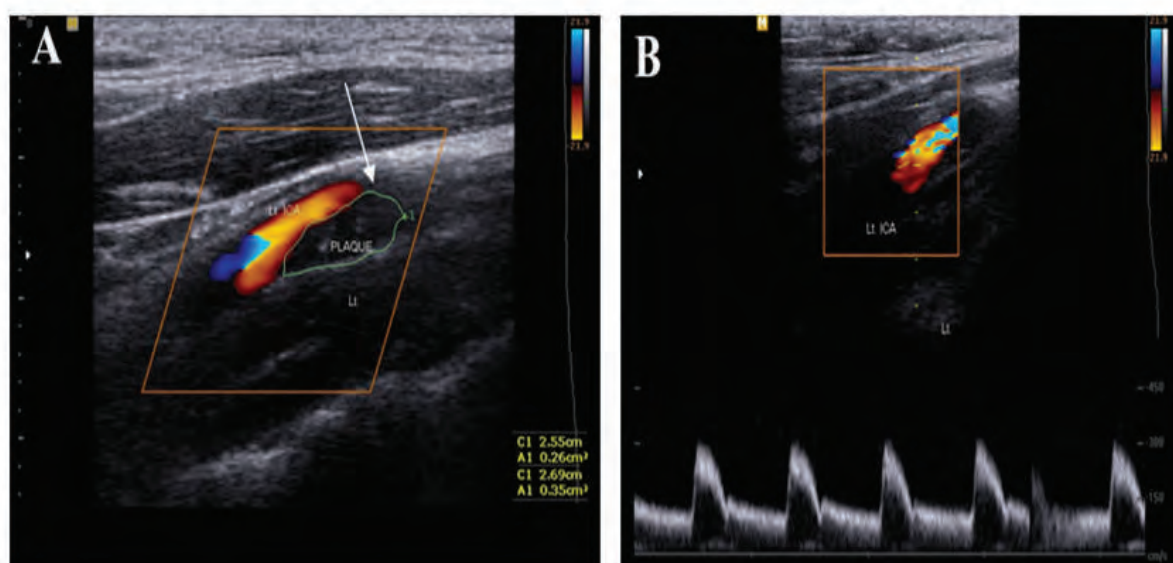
Colour duplex ultrasound of left carotid arteries showing:
